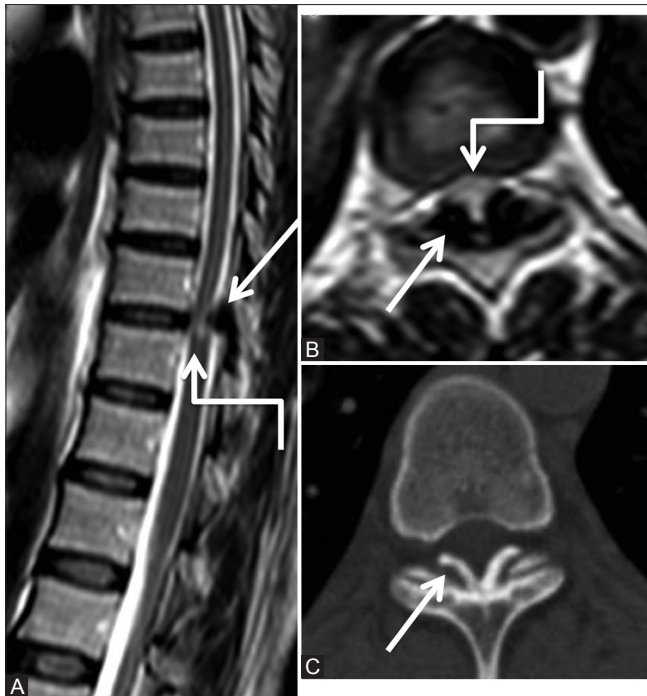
(A-C): Degenerative: Ligamentum flavum calcification: Sagittal (A), axial T2-weighted (B) and computed tomography (CT) axial (C) images of lower thoracic spine in 38-year-old female showing focal thickening of the ligamentum flavum (arrow) at lower thoracic level, which appears hypointense on T2-weighted images and shows calcification on the CT scan. These efface the posterior subarachnoid space and indent on the cord with edema in cord (elbow arrow)
